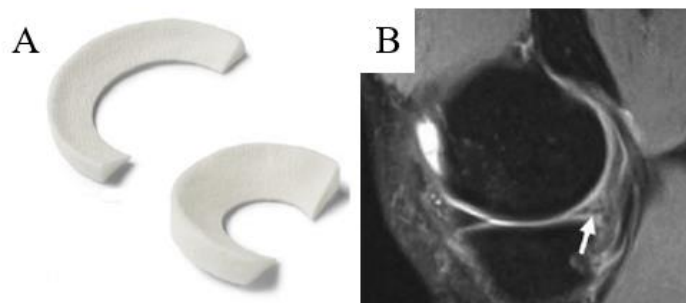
The CMI implant (A) for medial and lateral menisci and MR image of the implant (B) showing shrinkage after implantation (white arrow). [25]
